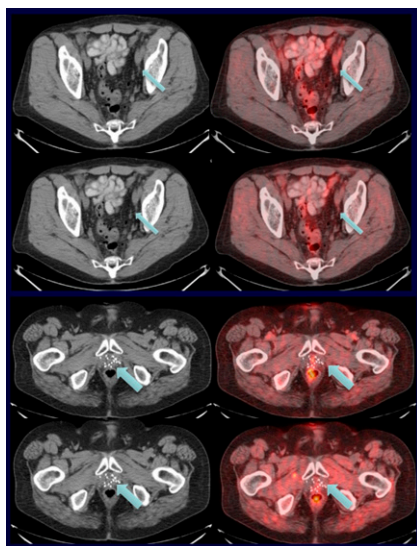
Single- vs dual-timepoint criteria with synthetic amino acid anti-3- ^{18}F -FACBC PET. Top: left external iliac lymph node with $\text{SUV}_{\text{max}}/\text{marrow } \text{SUV}_{\text{mean}} >1$ at 4 minutes (top row) and <1 at 17 minutes (next row) was defined as negative (true-negative) using dual time criteria. With early timepoint read criteria, the lymph node would have been misclassified as positive (false-positive). Bottom:
